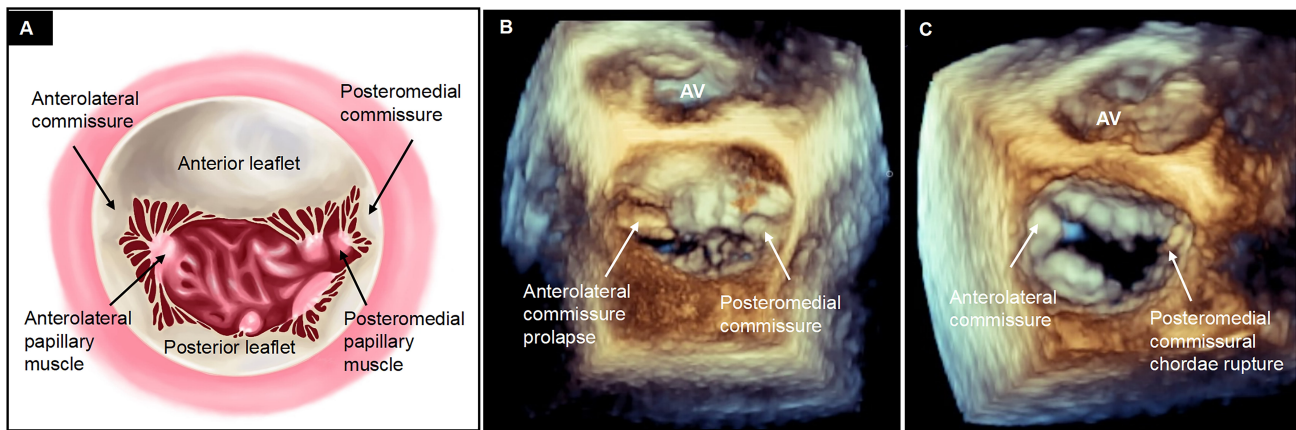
Definition of commissural degenerative mitral regurgitation. (A) Commissures, where anterior and posterior mitral leaflets converge during systole, typically form a Y-shaped structure by joining three segments (e.g., A1-anterolateral commissure-P1 or A3-posteromedial commissure-P3), distinguished by fanlike chordae tendineae stemming from anterolateral and posteromedial papillary muscles. Given the difficulty in distinguishing individual chordae on transesophageal echocardiography, the cleavage segment that separates the anterior leaflet from the posterior leaflet is used as imaging for anterolateral and posteromedial commissure approximation of true anatomic commissures. (B) The protrusion of the commissural segment into the left atrium during systole or (C) the rupture of commissural chordae tendineae characterizes commissural prolapse or flail [13]. AV, aortic valve.
